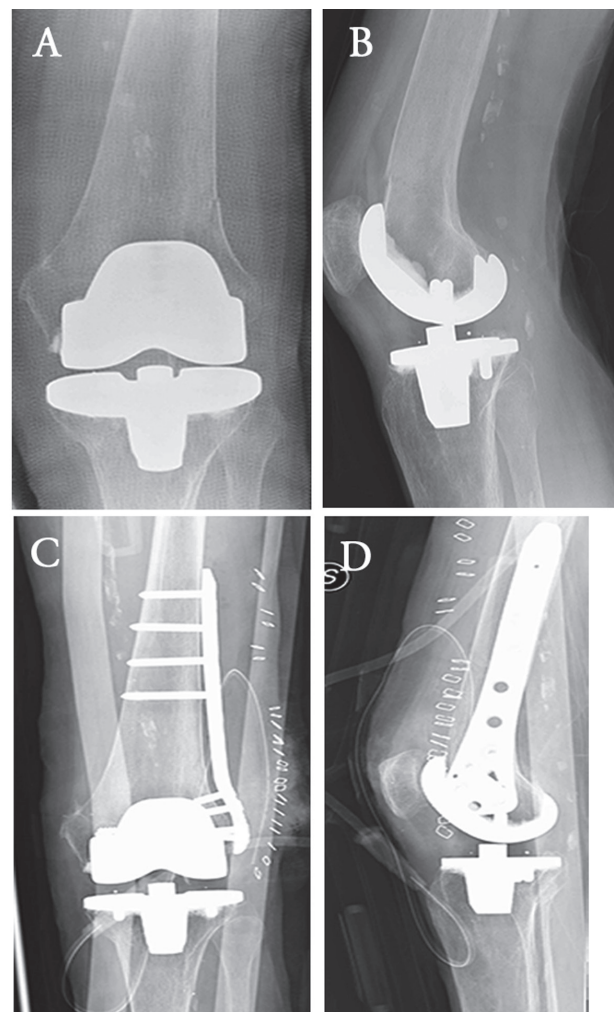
a, b) AP and Lateral x-rays of an undisplaced periprosthetic knee fracture of the distal femur (Rorabeck type I) in a 78yrs old female patient. c,d) AP and Lateral x-rays obtained after internal locking plate fixation
